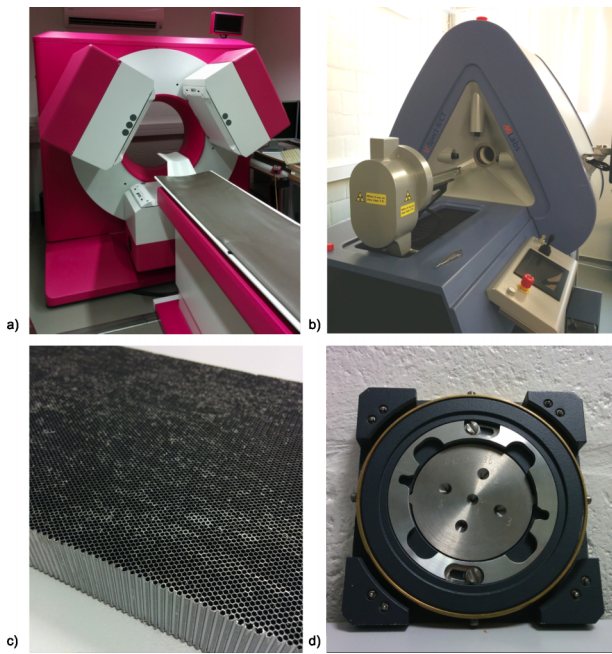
(a) The Prism 3000XP from Picker (Philips): a clinical triple-head SPECT system (b) The U-SPECT II from MILabs: A preclinical stationary SPECT system (c) A parallel-hole collimator (d) A multipin-hole collimator.
